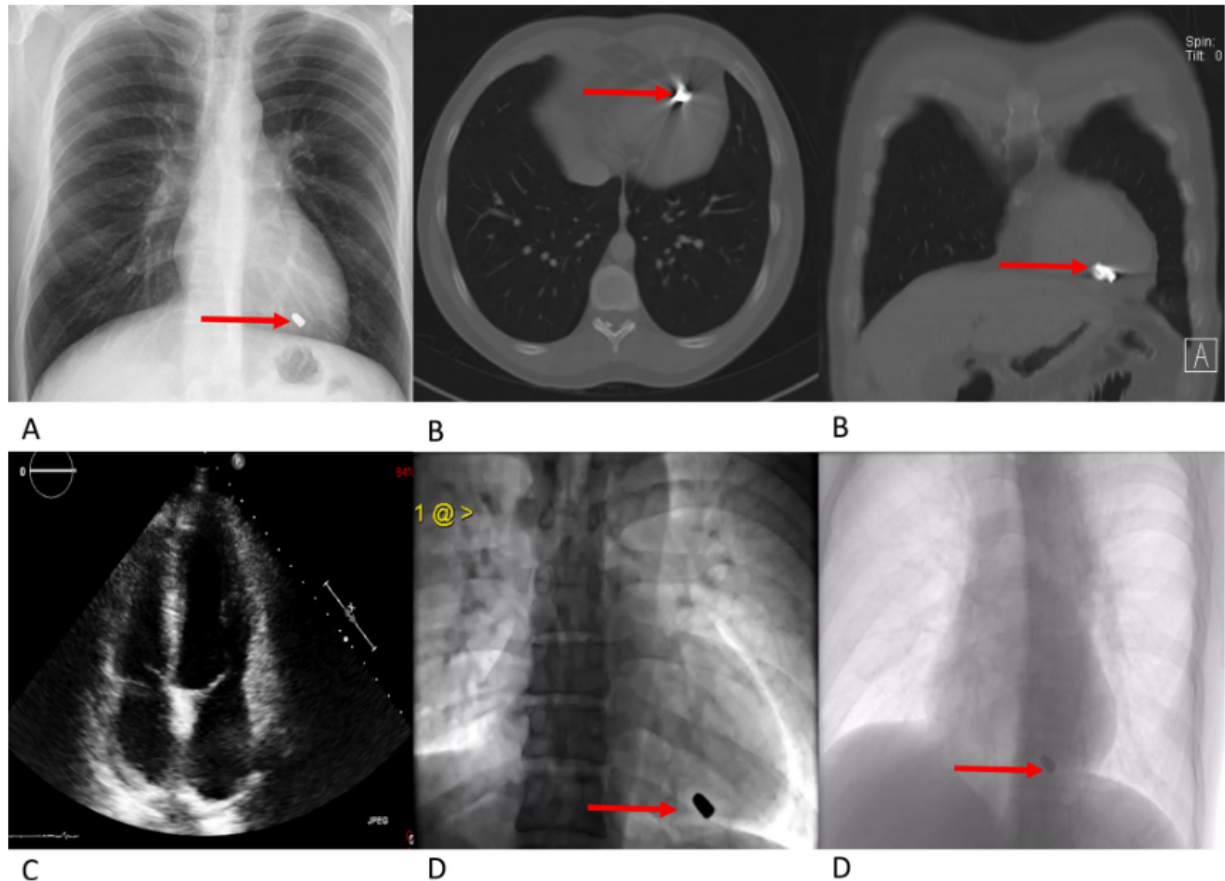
(A) Chest X ray, (B) Thorax CT and (D) Cardiac catheterization showing and artefact or bullet on the ventricular floor (red arrow). (C) Echocardiogram and (D) Cardiac catheterization showed no abnormalities in cardiac anatomy or physiology.
